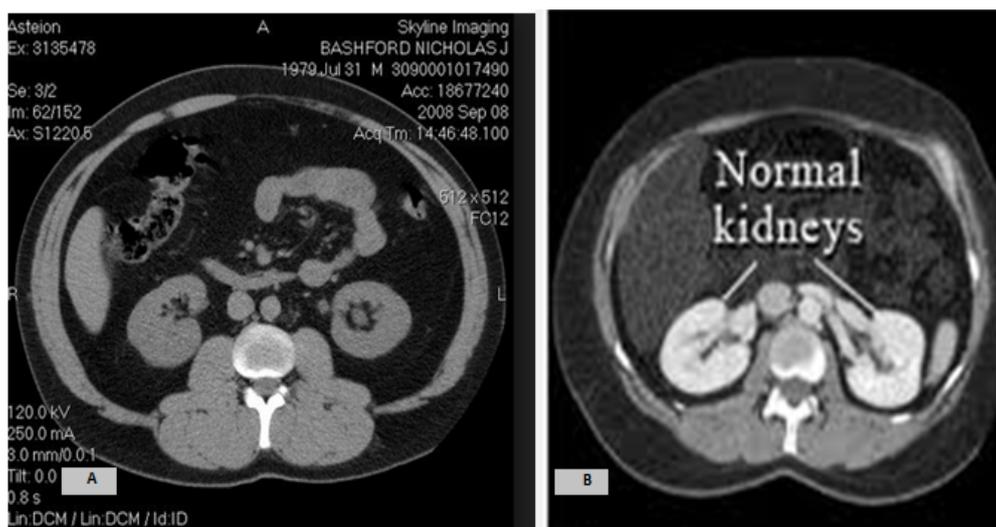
Normal CT anatomy. Unenhanced (A), with contrast (B)
